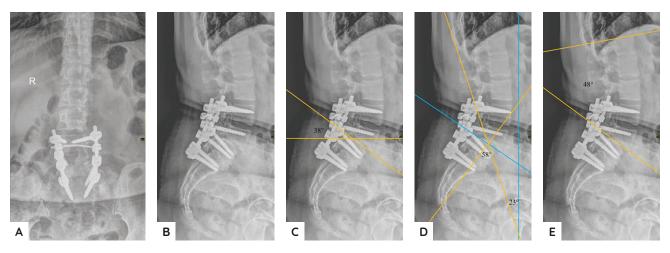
Showing lumbosacral AP-lateral X-ray post-operatively: AP (A); lateral (B); sacral slope (C); pelvic incidence and pelvic tilt (D); lumbar lordosis angle (E).
